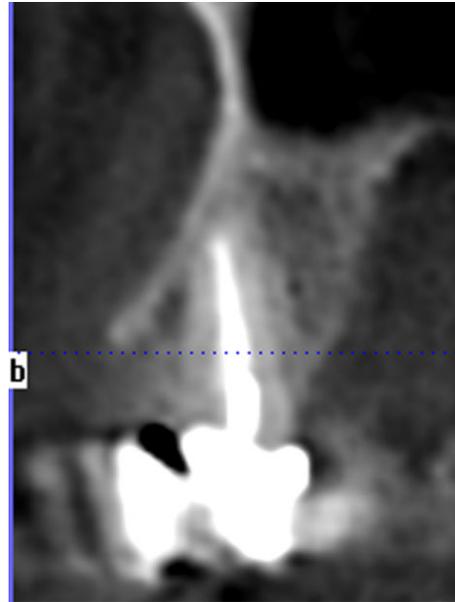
Preoperative CBCTs were taken on all patients to assess the extent of the defect prior to treatment. In this particular situation, the middle one-third of the labial plate was absent. B = buccal.
